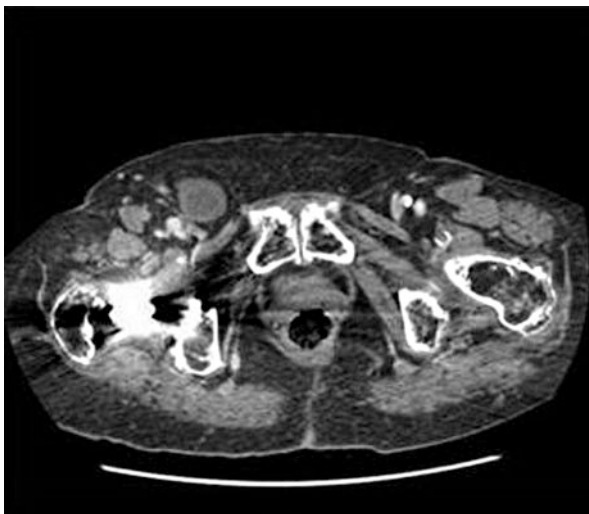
CT scan showing a *left* groin hernia. © Dale Dangleben, MD
